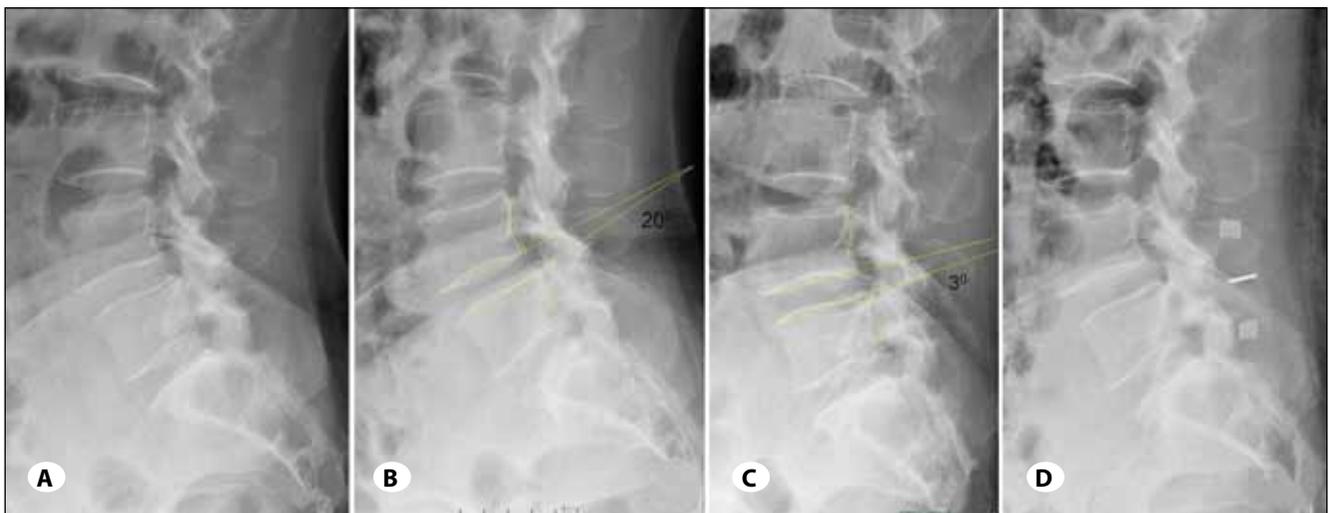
A 44-year-old female patient with lumbar instability. A) Lateral position film. B) Extension position film. C) Flexion position film. D) Neutral position film. Preoperative flexion-extension position X-ray showed lumbar spine instability. Postoperative X-ray at 1 year showed no loss of intervertebral height.
